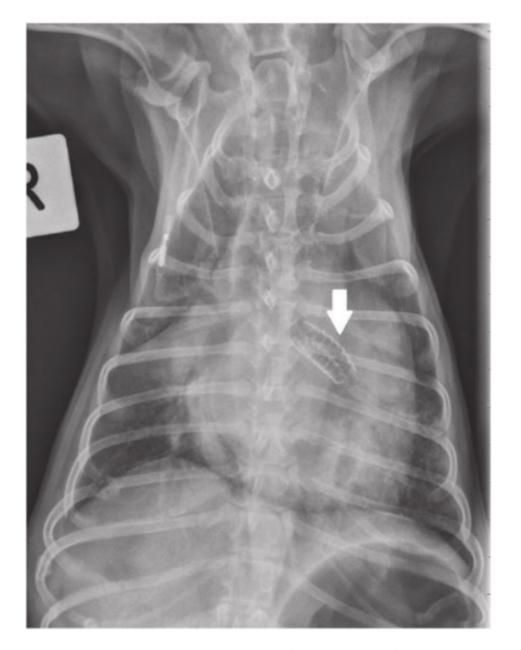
Dorsoventral thoracic radiograph of patient taken 30 minutes after stent placement. The stent is marked by the arrow, within the left mainstem bronchus
